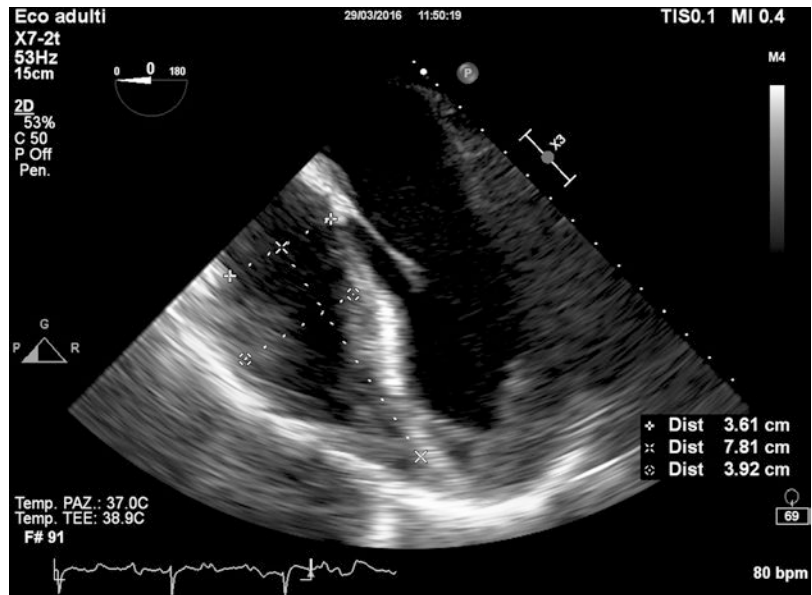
Transesophageal echocardiography. In the midesophageal four-chamber view, the diameters of the right ventricle are best assessed
